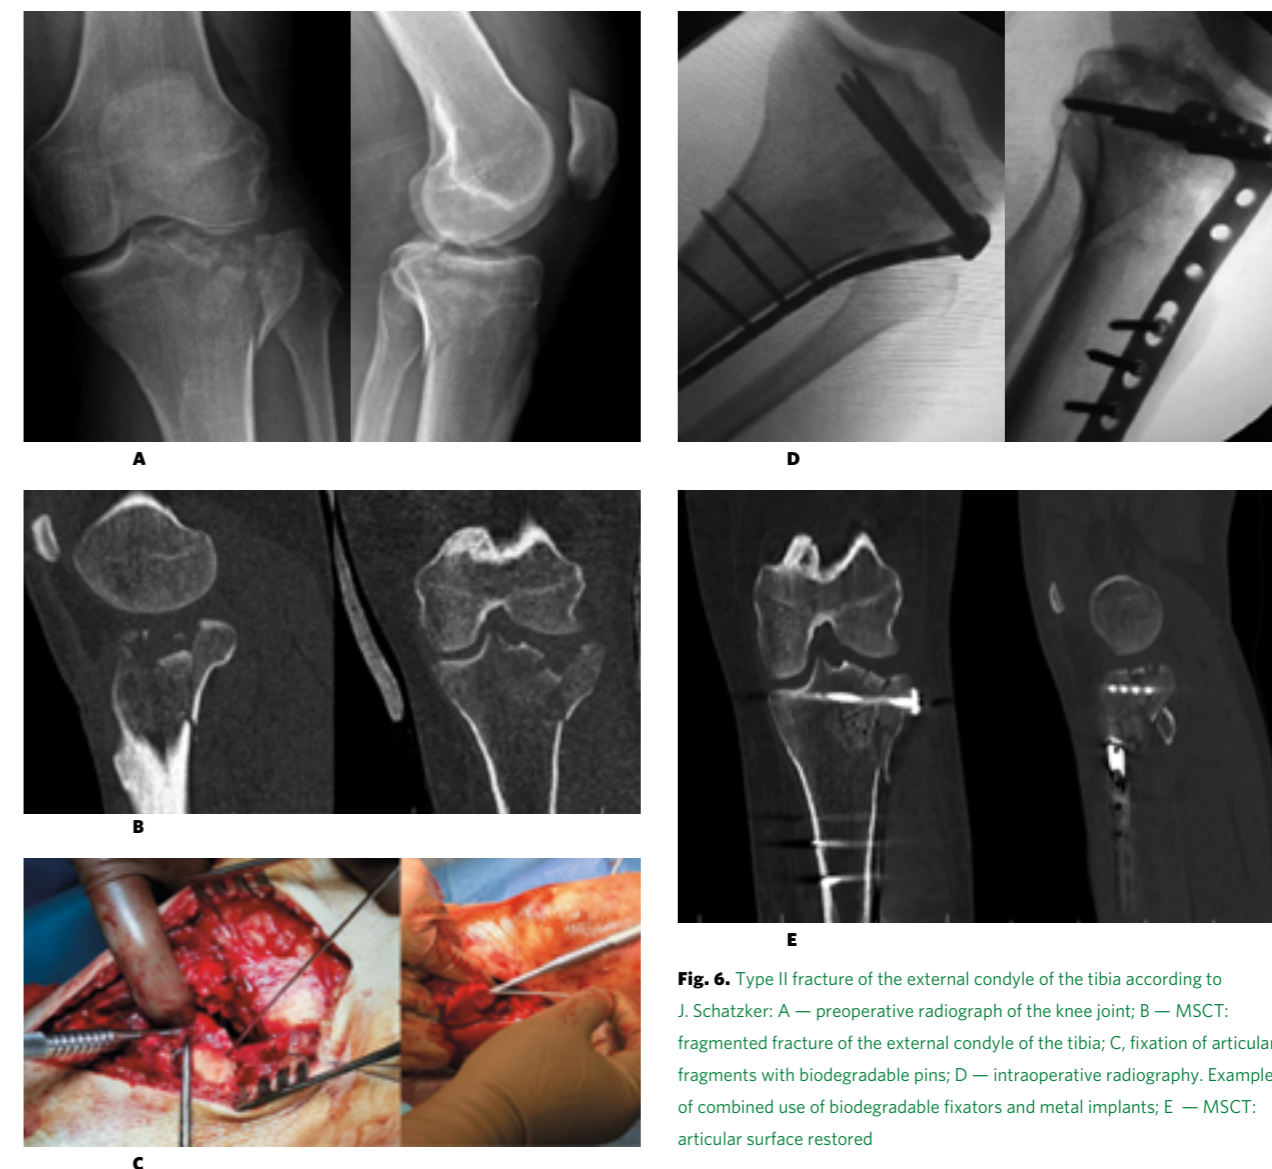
Type II fracture of the external condyle of the tibia according to J. Schatzker: A — preoperative radiograph of the knee joint; B — MSCT: fragmented fracture of the external condyle of the tibia; C, fixation of articular fragments with biodegradable pins; D — intraoperative radiography. Example of combined use of biodegradable fixators and metal implants; E — MSCT: articular surface restored
